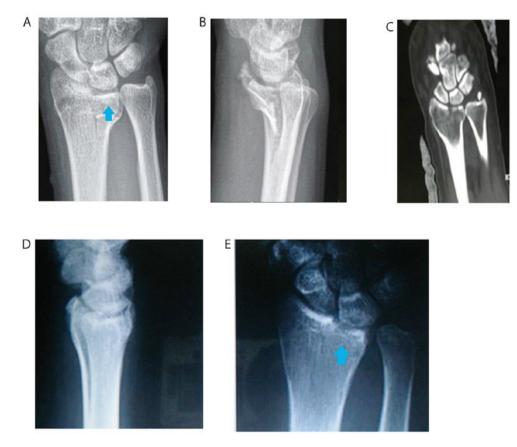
Conservative treatment of a type III fracture resulted in traumatic arthritis of the wrist. (A) Anteroposterior and (B) lateral radiographs of the fracture prior to treatment. (C) Anteroposterior and (D) lateral radiographs of the fracture after the treatment. (E) The arrow indicates the fracture site.
